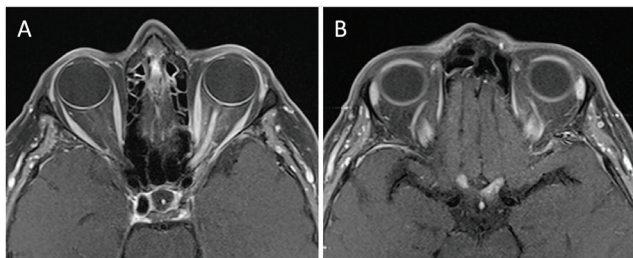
Gadolinium-enhanced magnetic resonance imaging of the brain (A, B) revealed the extended outline of the left part of the optic chiasm and the distal segment of the optic nerve with the cystic lesion. Visible abnormal enhancement after intravenous administration of contrast agent indicating the presence of inflammatory lesions in the left optic nerve, optic chiasm, and the right optic nerve near the optic chiasm
